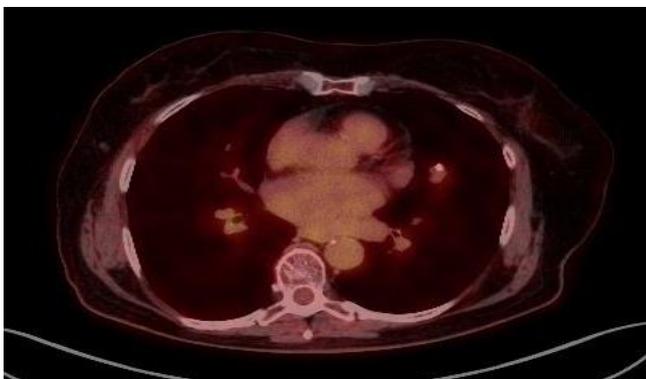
PET /CT showing a 1.5x1 cm nodule (SUVmax: 1.6) in left lung upper lobe
